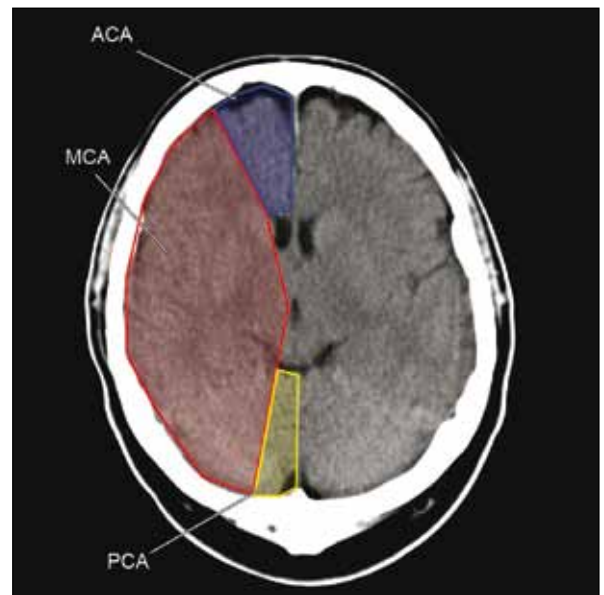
An annotated unenhanced computed tomography scan demonstrating the blood supply to the brain. Colours delineate the territory of the anterior (ACA; blue), middle (MCA; red) and posterior (PCA; yellow) cerebral arteries.
